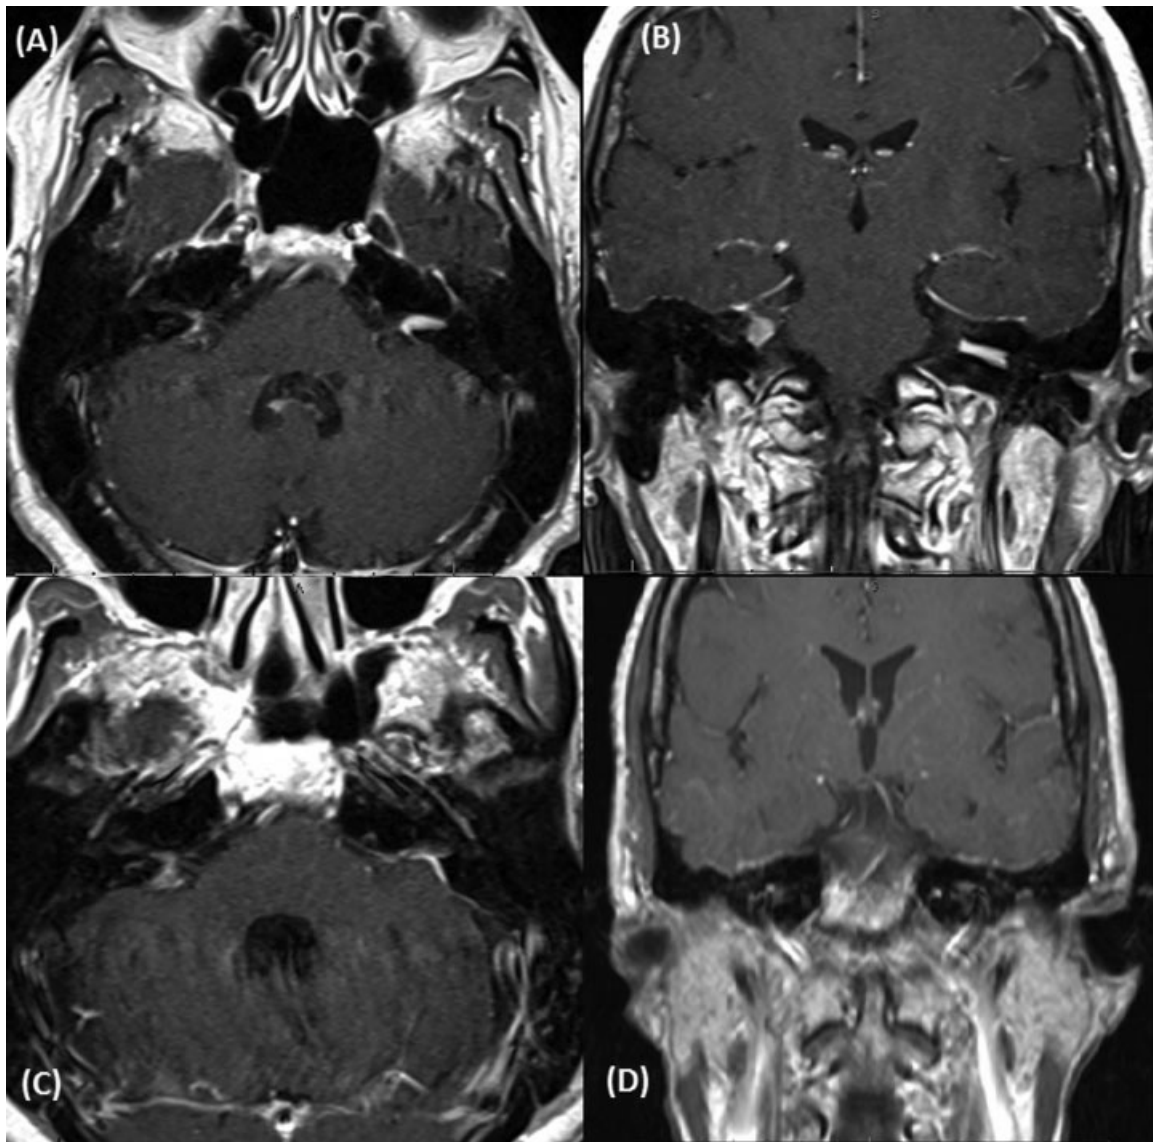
T1-weighted magnetic resonance images with gadolinium demonstrating (A) preoperative axial, (B) preoperative coronal, (C) postoperative axial, and (D) postoperative coronal images of a left intracanalicular vestibular schwannoma.
